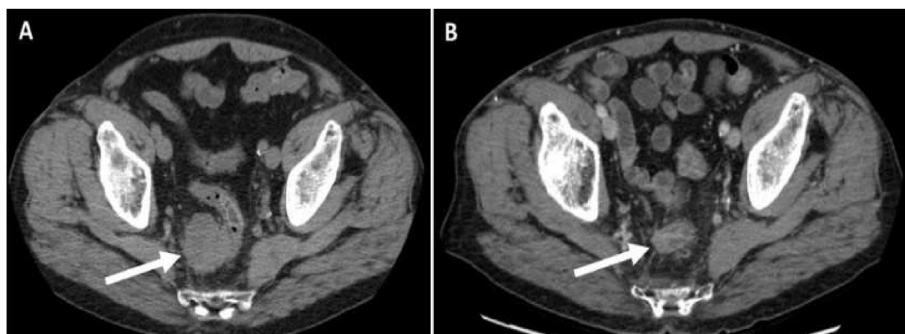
(A) CT imaging demonstrating right rectal wall mass measuring 4.8 cm AP x 4.1 cm transverse; (B) CT imaging 3 months later demonstrating marked decrease in tumor size to a soft tissue rectal wall prominence.
